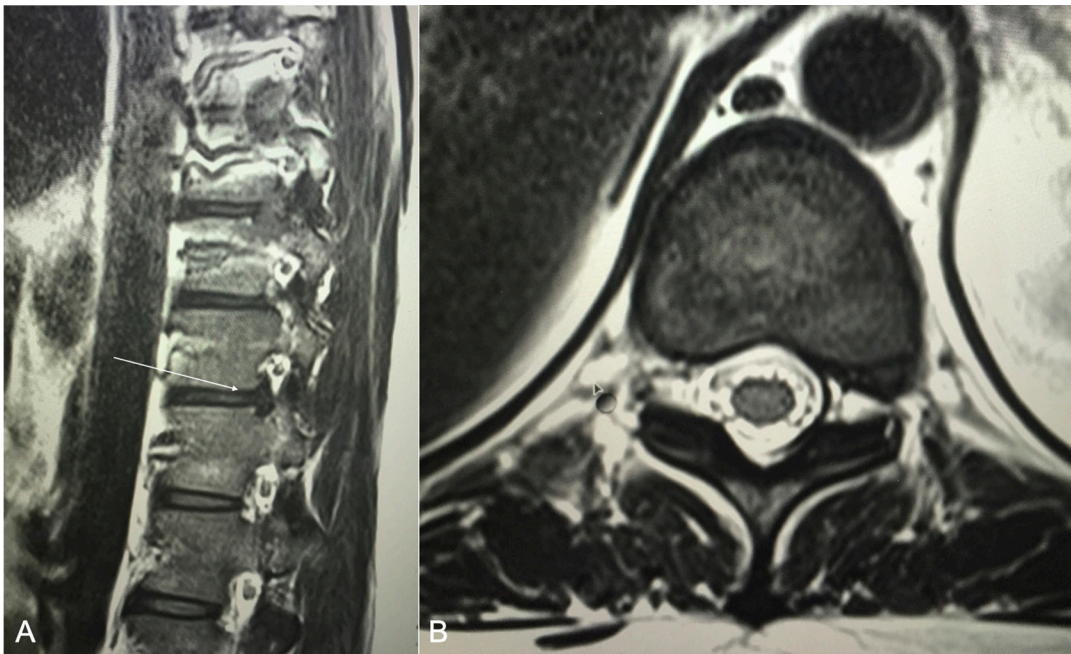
(A and B) Sagittal and axial T2-weighted magnetic resonance images of patient 1 showing a T10-T11 foraminal disc herniation.
